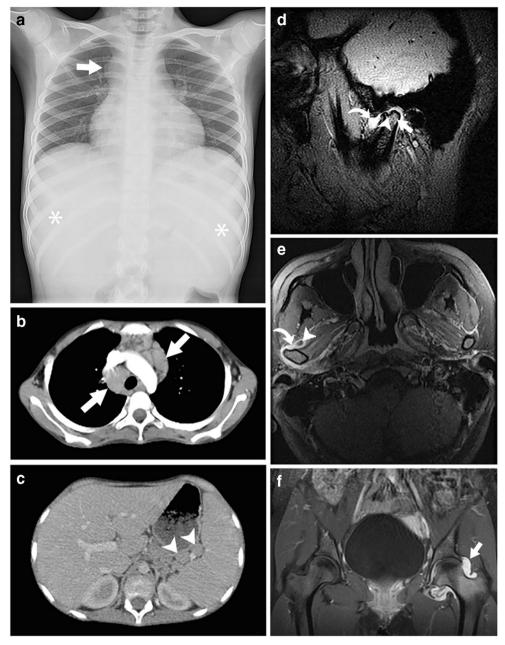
Systemic-onset juvenile idiopathic arthritis in a 10-year-old girl with daily fever, arthralgias for 1 year and a history of pericarditis. a Posteroanterior radiograph of the chest and abdomen shows mediastinal widening (*arrow*) and hepatosplenomegaly (*asterisks*). b Axial contrastenhanced computed tomography (CT) image of the chest confirms multiple enlarged mediastinal lymph nodes (*arrows*). c Axial contrastenhanced CT image of the abdomen shows several enlarged lymph nodes at the splenic hilum (*arrowheads*). d, e Four years later, the child presented with deviation of the mandible to the right on the mouth opening. Sagittal T2-weighted gradient echo magnetic resonance imaging (MRI) of the right temporomandibular joint (d) shows an
